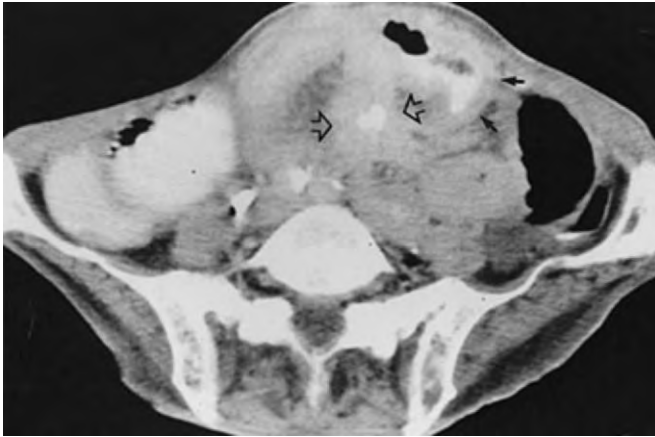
Computed tomography scan of the lower part of the abdomen. Dilated bowel loops surround a large mesenteric mass (*open arrows*). In one bowel loop, wall thickening is demonstrated (*solid arrows*).
